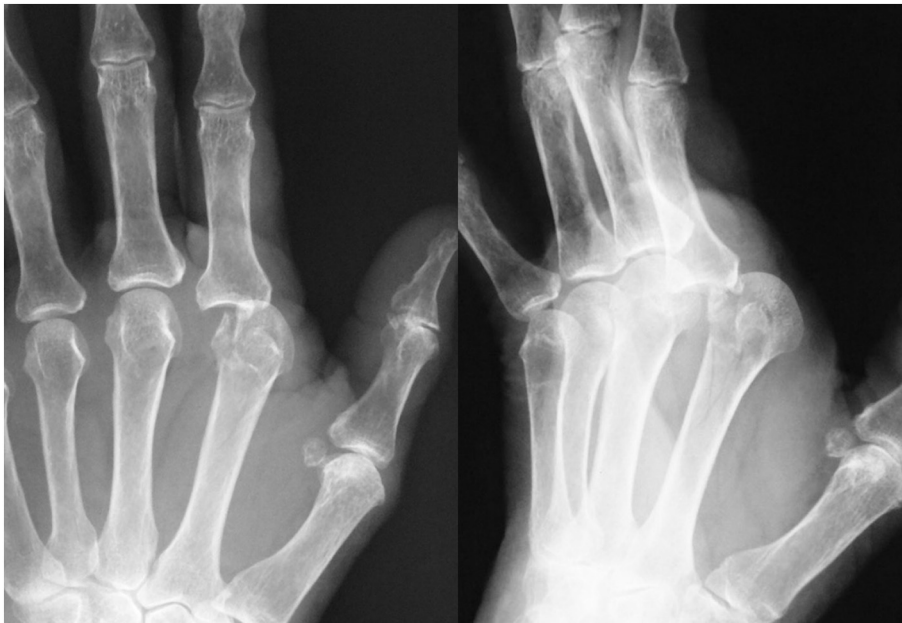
Radiography showing dorsal dislocation of the MP joint.
